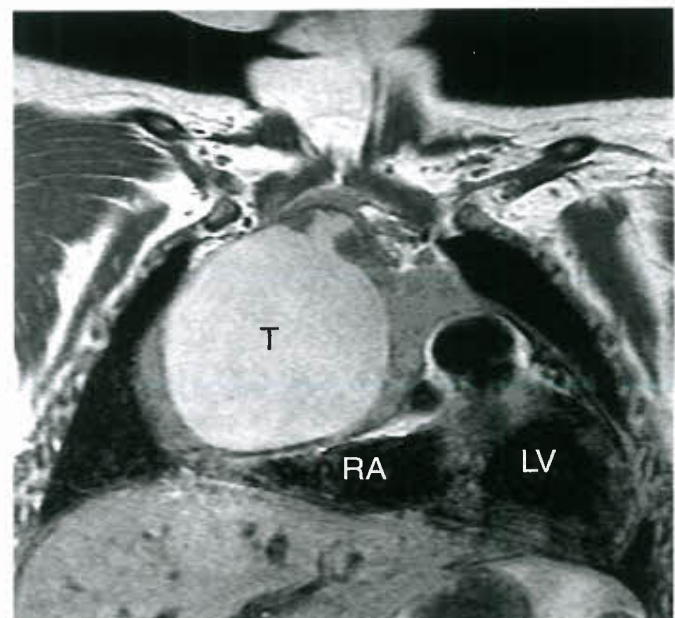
Coronal plane T1-weighted FSE image in a patient with pericardial teratoma (T). Note the compressed RA. LV, left ventricle.
